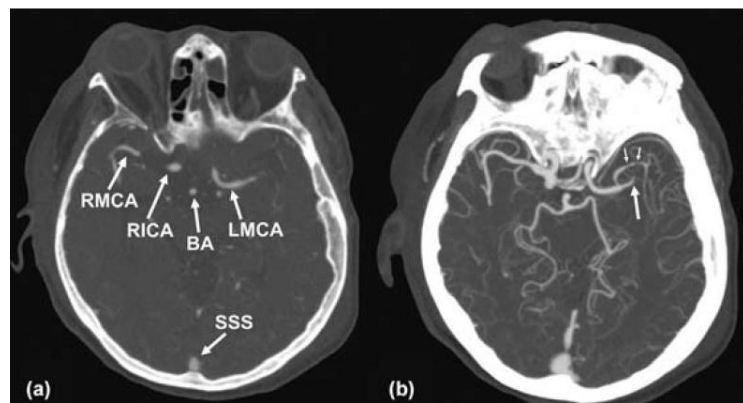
CT angiography.
